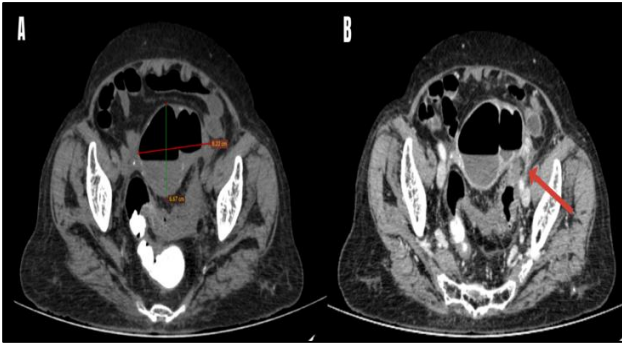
CT abdomen axial view (A) Plain showing collection in uterine cavity with thickened sigmoid colon (B) Contrast scan showing fistulous tract between sigmoid colon and uterine cavity with leak of contrast into the collection (red arrow).
